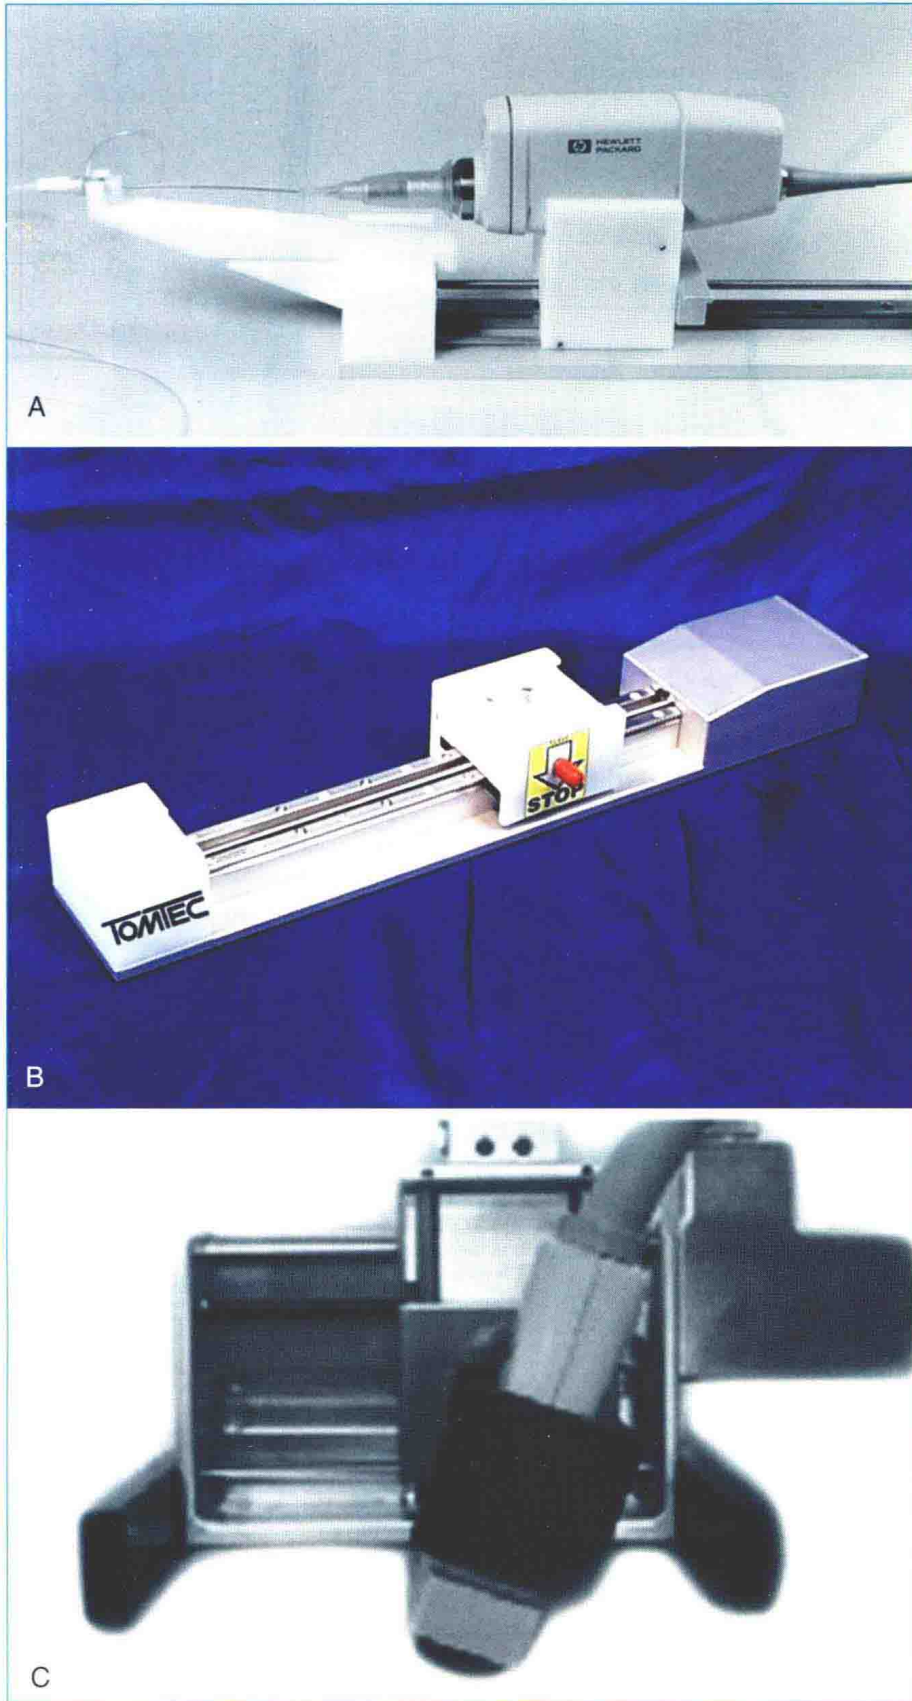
Parallel, or linear, scanning. In these iterations of three-dimensional scanning, the transducer was moved in a linear, stepwise fashion. A and B, The linear stepper device for use with an intravascular ultrasound device. C, A linear stepper for a transthoracic transducer. (Courtesy TomTec, Inc., Munich, Germany.)
